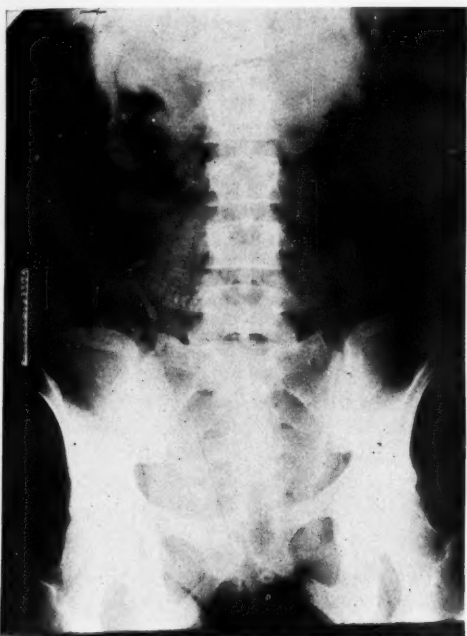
X-ray of pelvis showing skeleton of fetus in region of right iliac fossa.
